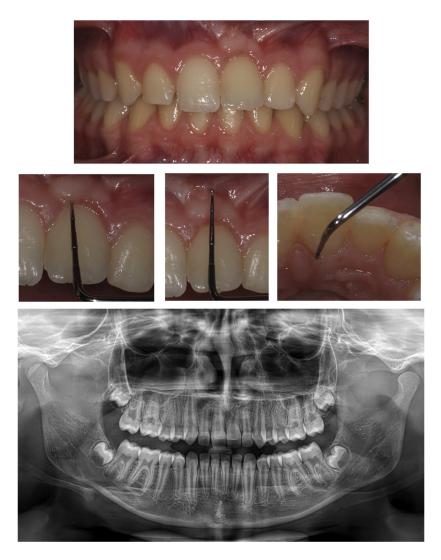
Two-year follow-up. A, keratinized gingival width (3 mm); B-D, clinical probing depth from 1 to 2 mm. E, final panoramic radiograph shows the root of the dilacerated tooth increased in length, and no incisor root resorption is evident.
